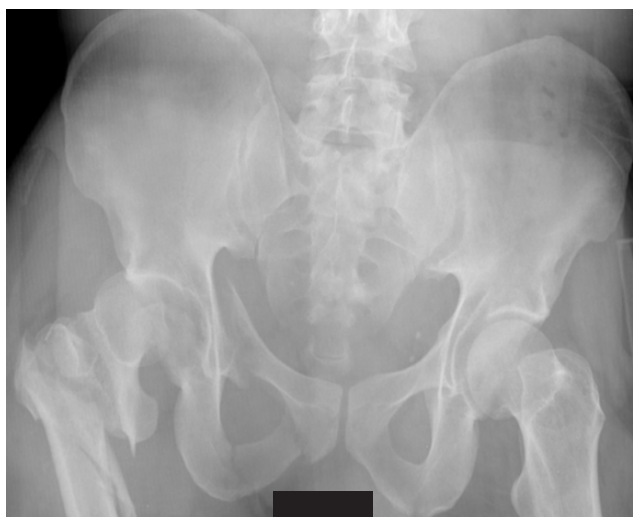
Anteroposterior pelvis plain film shows right femoral head fracture-dislocation with intertrochanteric femur fracture as well as right superior and inferior pelvic rami fractures.
